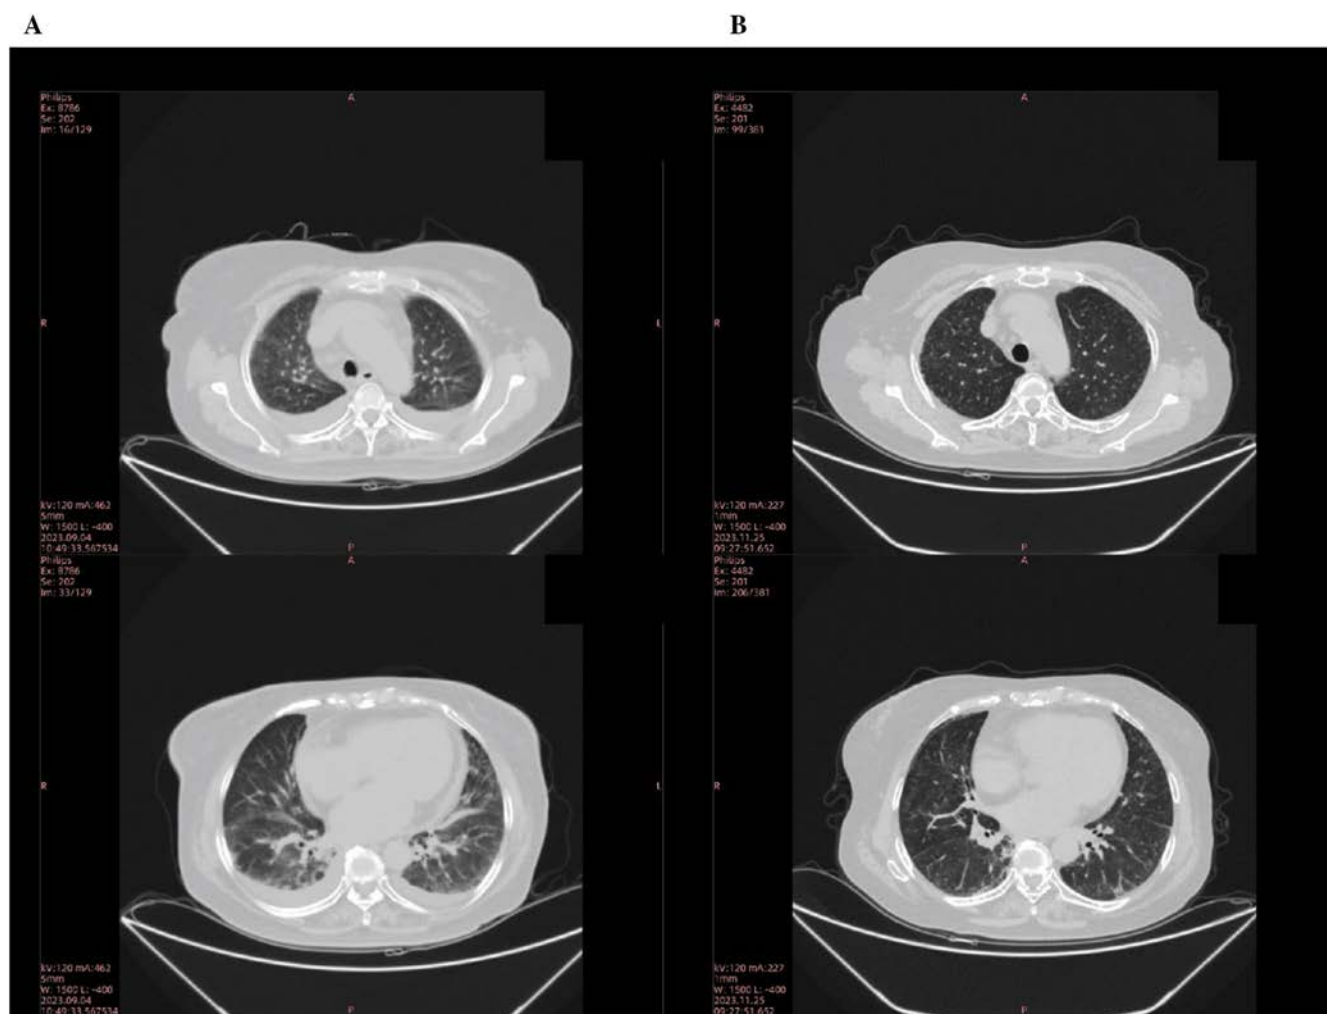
Images from chest radiography and high-resolution computed tomography. (A) Chest CT at the time of administration with Telitacicept. (B) Chest CT after 2 months of Telitacicept use.
